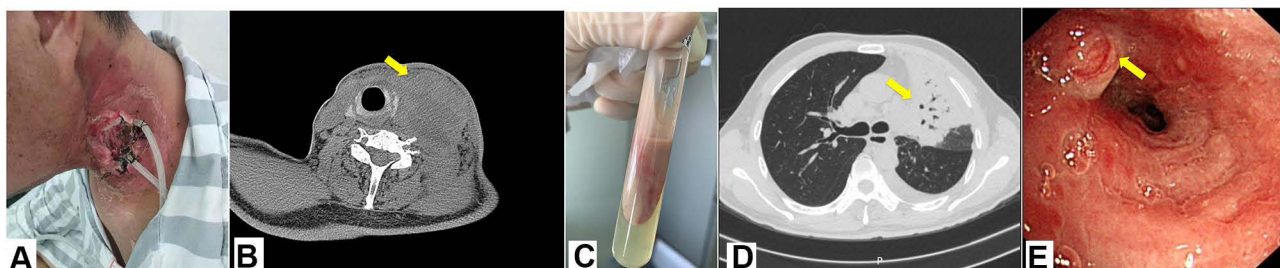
Neck CT findings. Mixed-density lesions on the left side of the neck (A). The masses were incised, and a drainage tube was inserted (B). Pus and necrotic materials (C). A large new exudative consolidation shadow was noted in the left upper lobe after 2 weeks of antibacterial treatment (D). Bronchofibroscopy revealed bronchial nodules in the left upper lobes that obstructed the lumen. Mucosal hyperplasia and hypertrophy were also noted (E).
